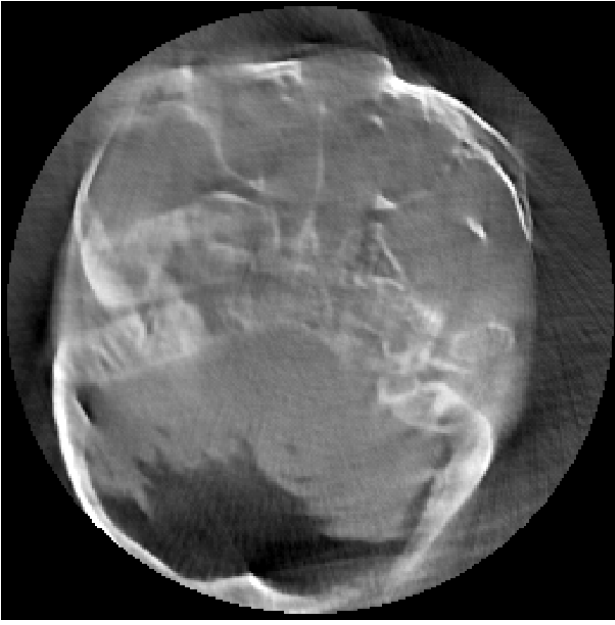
Example of CT artifacts induced by patient movement during the data acquisition.
